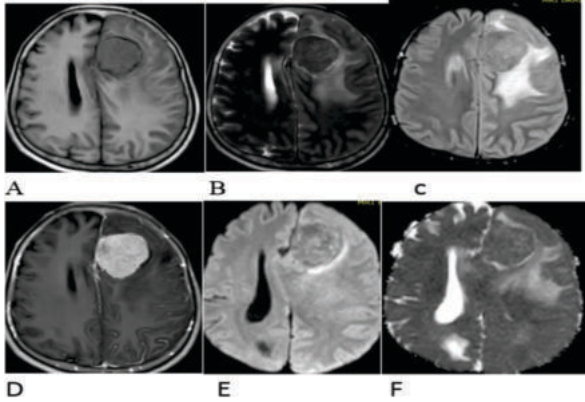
A) Axial T1 weighted MR image showing well defined extra axial mass lesion which is isointense to grey matter with surrounding edema in left frontal lobe B) on T2 weighted MR image the lesion is isointense to grey matter C) on FLAIR images the lesion is not getting suppressed D) on post contrast T1 weighted images the lesion is showing intense homogenous post-contrast enhancement E) and F) DWI and ADC the lesion is showing restriction similar to brain parenchyma with ADC values 1.1×10^{-3}
